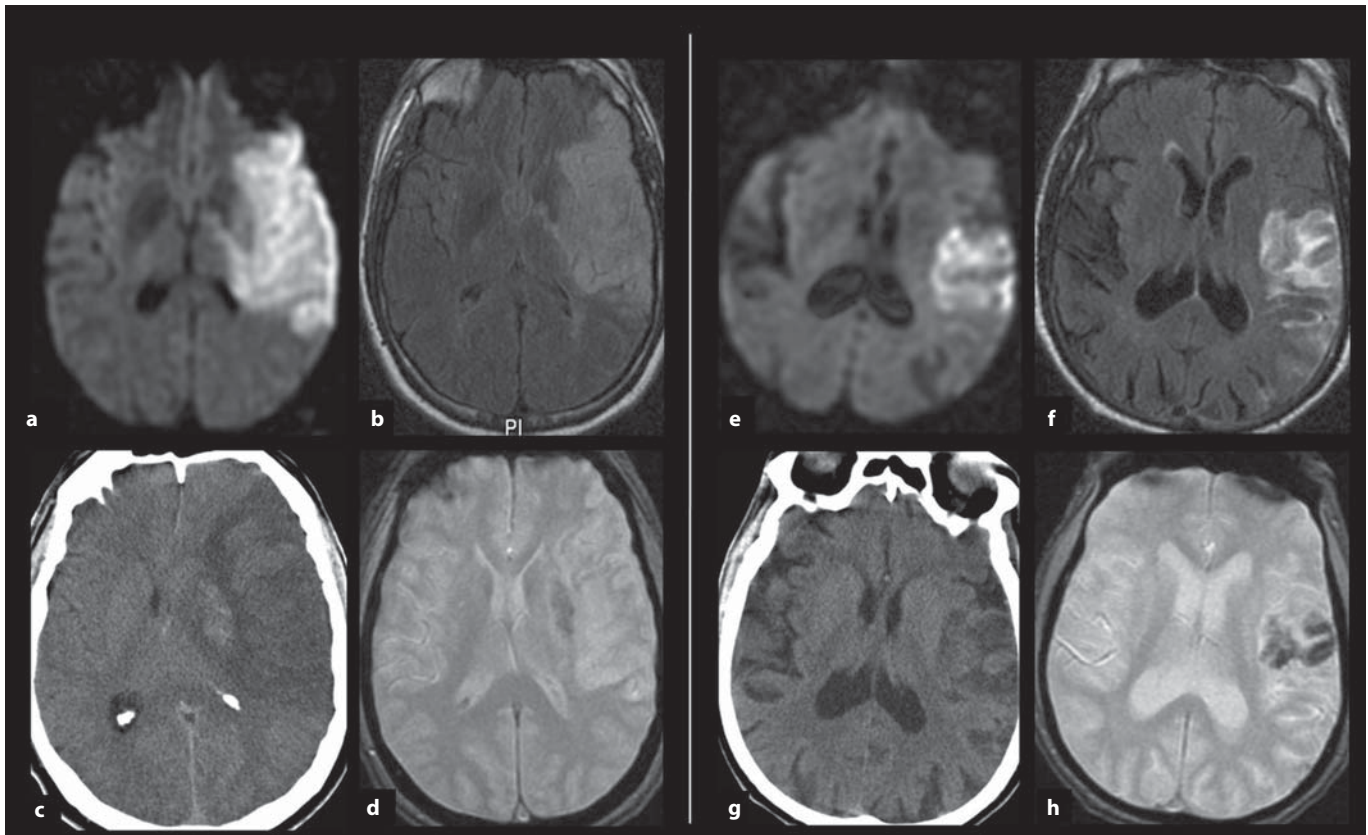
Two ambiguous examples of bleeding detection (patient 1: a–d, patient 2: e–h). Hyposignal within lenticular nuclei on DWI (a) and FLAIR (b) sequences that can be interpreted either as bleeding or as susceptibility effect of the physiologic iron accumulation. In this case, noninjected CT (c) shows hyperdensity and T2*GRE (d) shows clear and asymmetrical hyposignal, confirming HT. Hypointensity on DWI (e) and FLAIR (f) sequences and isodensity on CT (g) within the ischaemic area which can be considered either a petechial haemorrhage or tissue spared by the ischaemic process or sulcus. The hyposignal on the T2*GRE (h) sequence confirms the HT.
